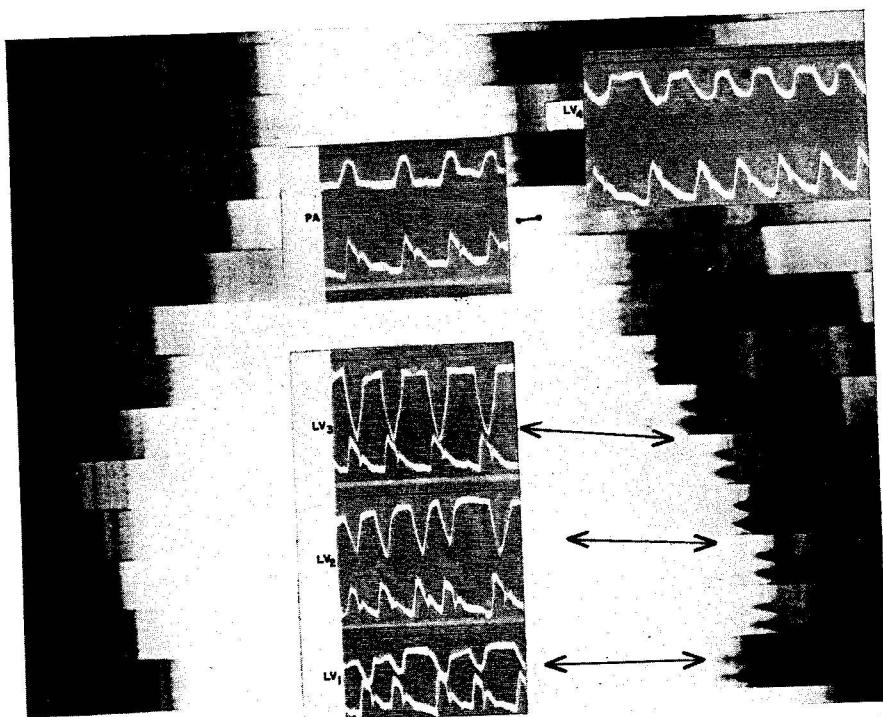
This patient, case 2 (1), had auricular fibrillation at the time of these pre-operative EKY's and RKY's. The EKY's show, in addition to the characteristic ventricular border pattern, abnormally flat diastolic intervals in the pulmonary artery tracings (PA). There are late systolic plateaus in LV4. The roentgenkymogram, in addition to revealing conspicuous diastolic plateaus, demonstrates, first, the large amplitude of pulsations at the left border in spite of generalized pericardial involvement and secondly, the effect of calcification in producing obliteration of the diastolic plateaus. Note the evidence of calcification on the left border.
